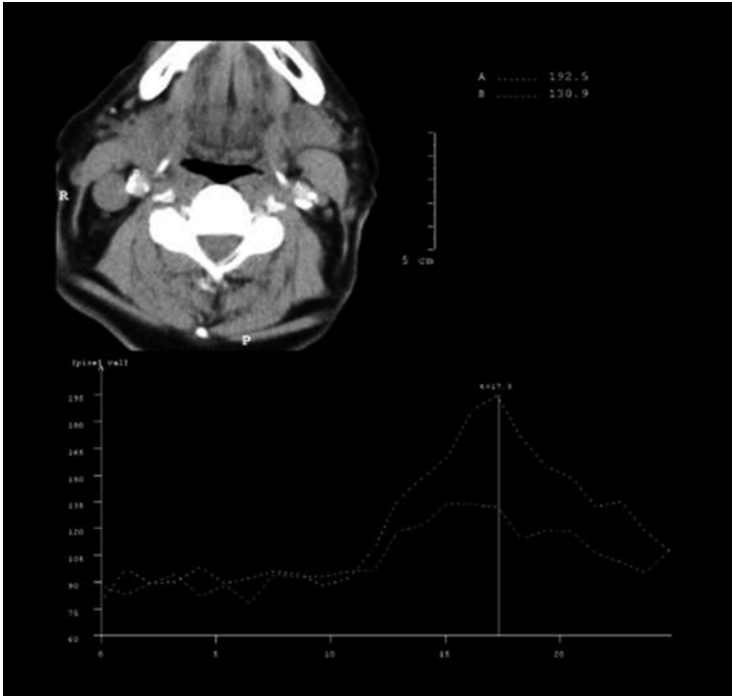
Low-dose axial CT image performed during test bolus of contrast injection with ROI placed over the region of the carotid bifurcations and revealing peak contrast enhancement 17 s after injection initiation
